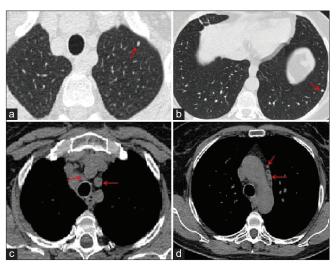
Chest CT. In the axial images, intraparenchymal lung micronodules (red arrows) (a and b) and mediastinal lymph nodes (red arrows) (c and d) are visible. CT: Computed tomography
